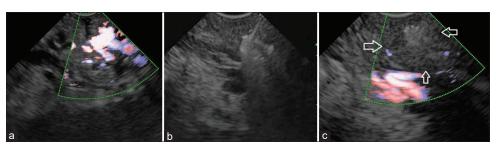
(a) EUS: Gastric varices with flow on Doppler. (b): EUS-guided coil injection into the gastric varices. (c) EUS after 5 min injection of coil and glue demonstrates the absence of flow on Doppler (arrows)
